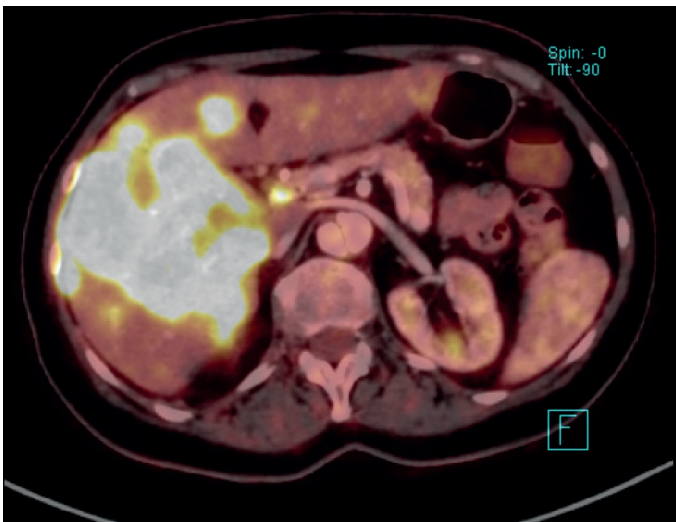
Multiple metastases of colorectal carcinoma in the liver and aortic dissection (PET CT).
